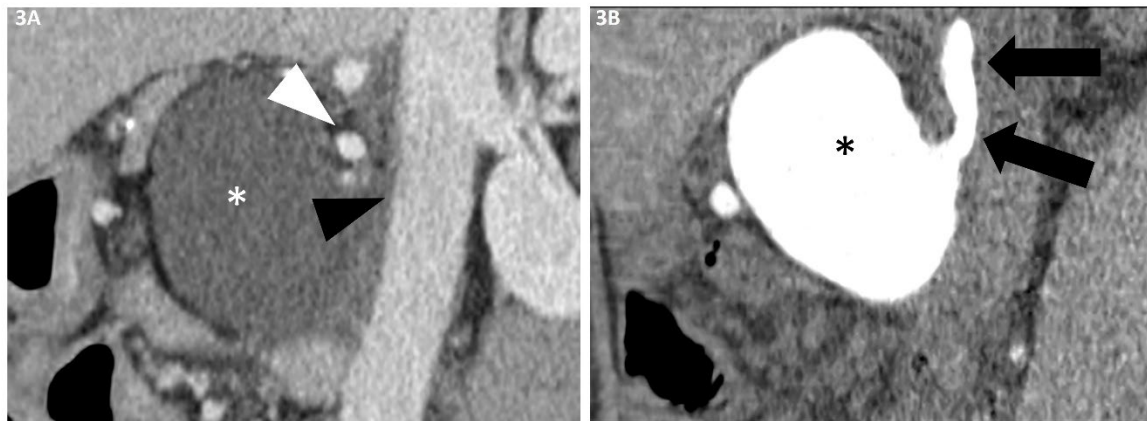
(A) CT scan performed on postoperative day 40 before pressurized contrast injection in the lymphocele (*). The tubular connection located between the superior mesenteric artery (white arrowhead) and inferior vena cava (black arrowhead), was barely filled with fluid and remained unnoticed. The lymphocele is shown in the sagittal plane on CT scan. (B) After pressurized contrast injection through a trans-omentally placed catheter (not shown), a lymphopseudoaneurysm (black arrows) draining into the lymphocele (*) close to the location of the surgery becomes visible.
